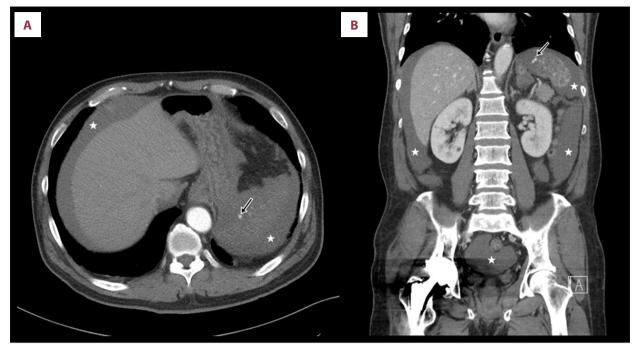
Contrast-enhanced computed tomography (CT) scan of the abdomen performed in the emergency department. Splenic arterial hemorrhage (arrow) and hemoperitoneum (white star) are shown in the axial (A) and coronal (B) images.
